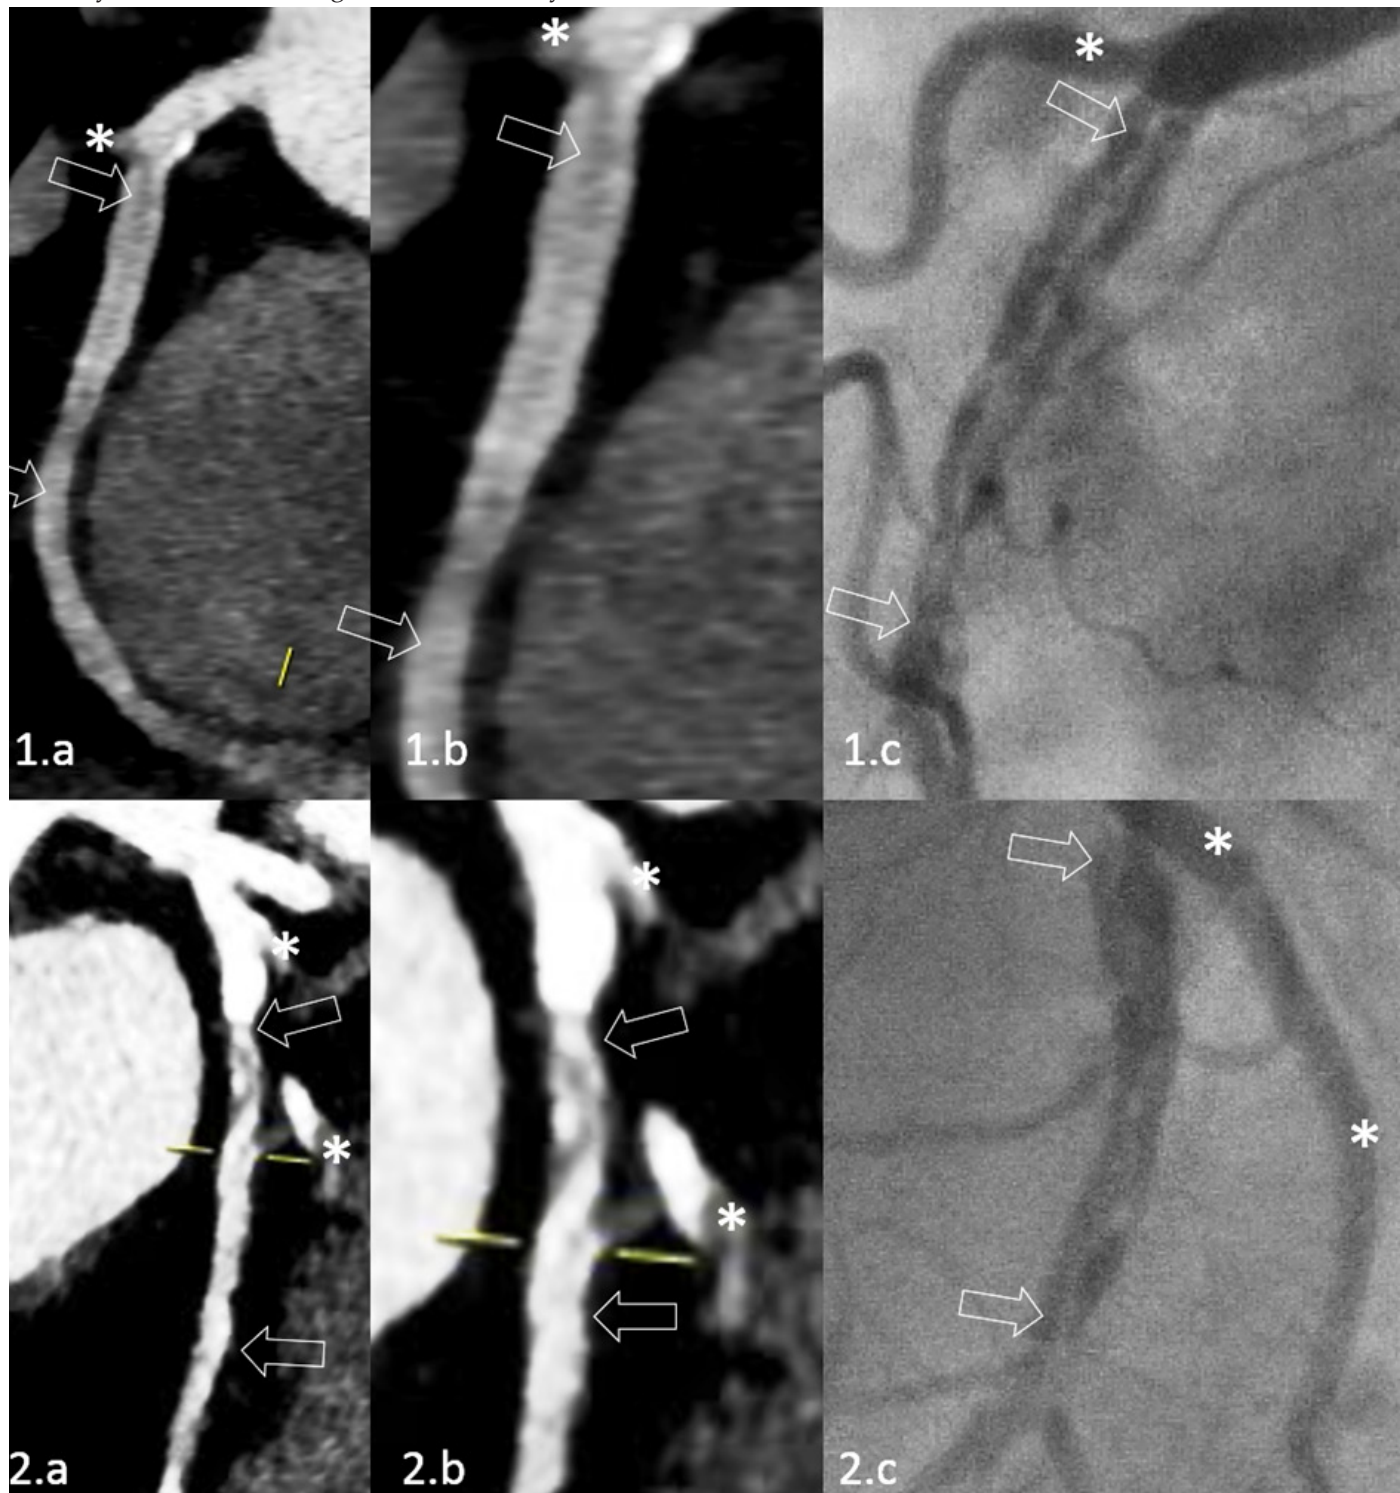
Computed tomography views: Panel 1a shows the RCA view with the right ventricle branch take-off indicated with a white asterisk (*); white arrows indicate the lesion length featured with the dissection of the tunica intima. Panel 1b is the magnified view (x 1.8). Panel 1c is corresponding coronary angiography with the clearly visible dissection of the inner wall of the artery (indicated with white arrows). Panel 2a shows the mid LAD with the visible IGD take-off (indicated with *) and the lesion length (indicated with white arrows) featuring typical signs of dissection of the tunica intima. Panel 2b is the magnified view (x 1.8). LAD - left descending artery, RCA - right coronary artery, IGD - 1st diagonal branch
